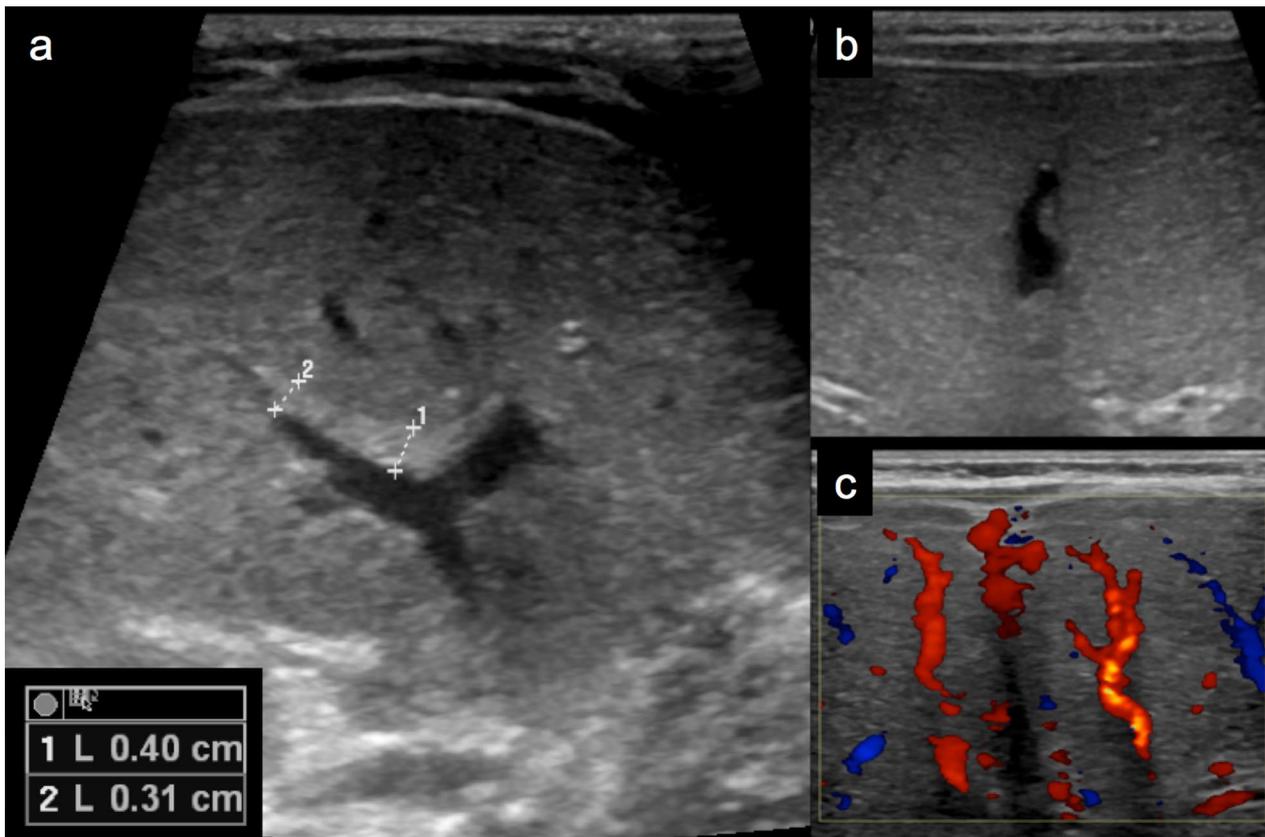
Biliary atresia. Ultrasound images show the typical findings of BA: triangular cord (a), gallbladder ghost triad (atretic gallbladder, irregular or lobular contour and lack of smooth/complete echogenic mucosal lining with an indistinct wall) (b) and hepatic subcapsular flow (c)
